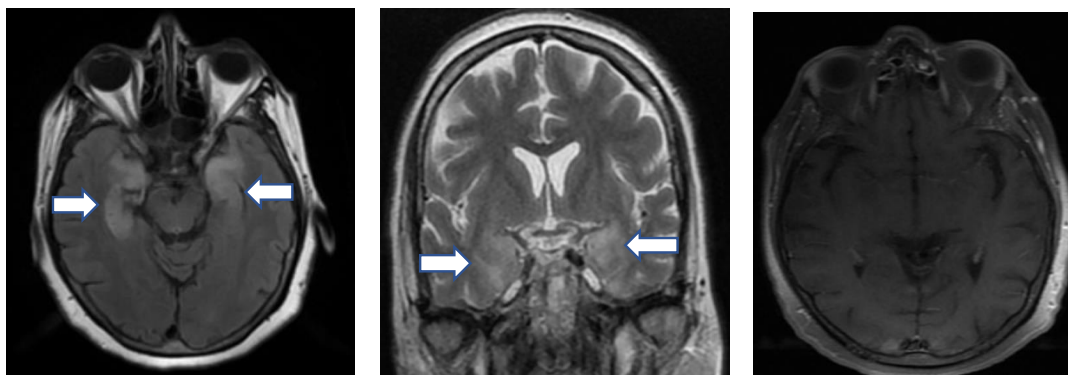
Fluid-attenuated inversion recovery (FLAIR) axial and coronal images demonstrating T2/FLAIR hyperintensity of the bilateral hippocampus (white arrows). Axial T1-weighted postcontrast images showing no gadolinium enhancement.
